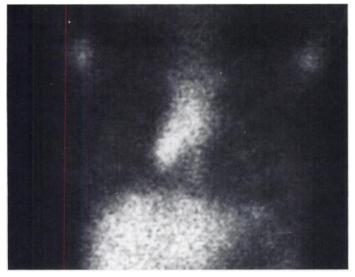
Anterior planar image of the chest and upper abdomen obtained 72 hr after the injection of 255 MBq (6.9 mCi) ⁶⁷Ga citrate. A large area of abnormally increased tracer activity is seen in the mediastinum similar to that seen in the FDG/PET image obtained 16 days after the ⁶⁷Ga study.
